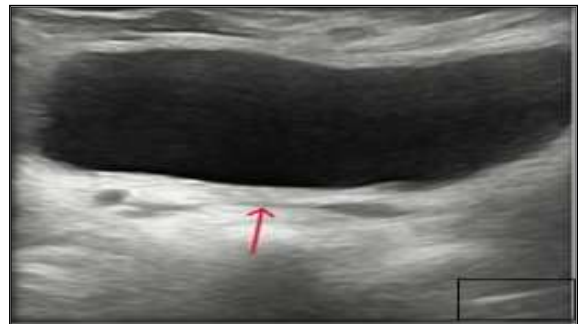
shows Ultrasound images of absent uterus.
